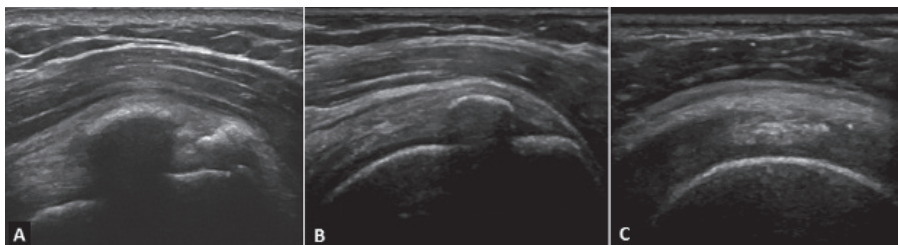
sonographic findings of calcific deposits as described by Farin et al.. (A) A hyperechoic focus with a well-defined shadow; (B) a hyperechoic focus with a faint shadow; and (C) a hyperechoic focus with no shadow.
